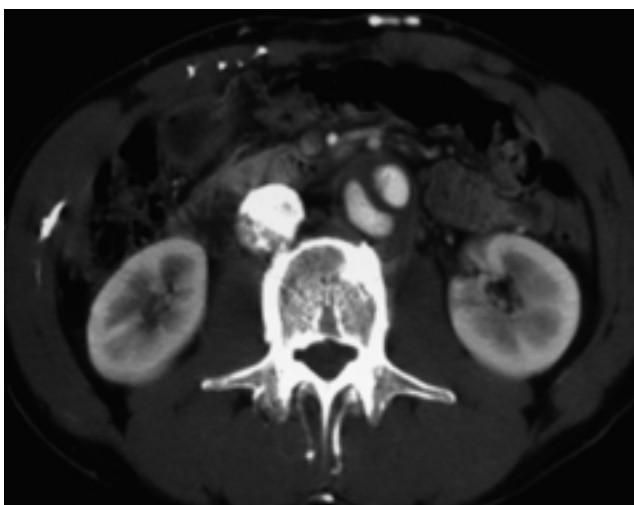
Abdominal CT shows a pseudoaneurysm at infrarenal aorta.
